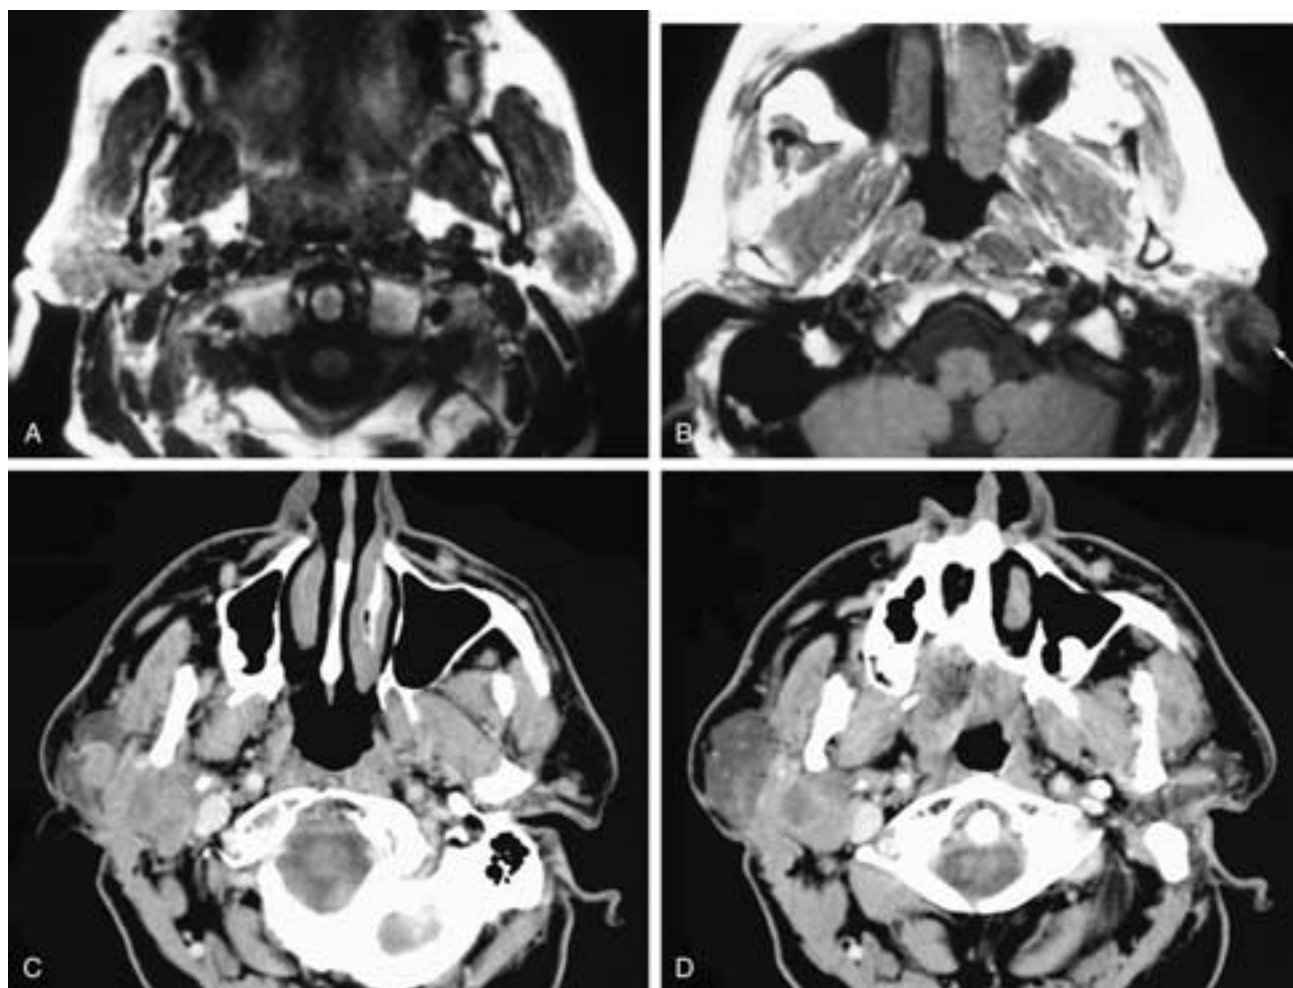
Axial T1-weighted MR images through the parotid gland (A) and the pinna of the left ear (B). There is a poorly defined low signal intensity mass in the left parotid gland. This mass also had low T2-weighted signal intensity. The imaging findings suggest a high-grade tumor. In B, there is a mass in the left ear pinna (arrow). This patient had metastatic disease to the parotid gland from a primary SCC of the ear. Axial contrast-enhanced CT scans (C, D) on another patient show multiple poorly defined masses in the right parotid gland. Some lesions are necrotic. This patient had metastatic SCC from a scalp primary.
